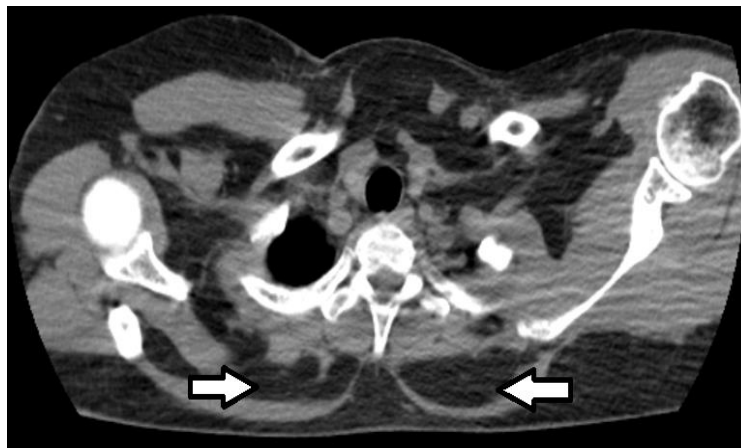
Axial CT scan in mediastinal window showing an accumulation of unencapsulated fat beneath trapezius muscle (arrows)
